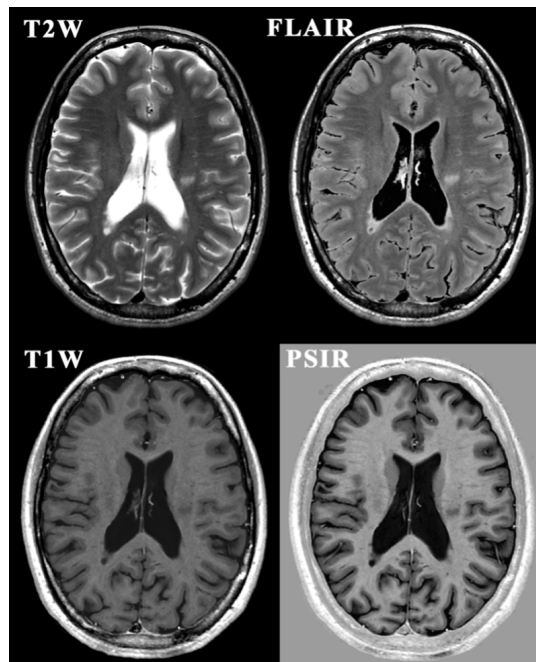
Examples of SyMRI images, based on the T1, T2, and PD maps of Fig. 2 including FSE images such as T1W and T2W as well as IR-FSE images such as FLAIR and PSIR.
